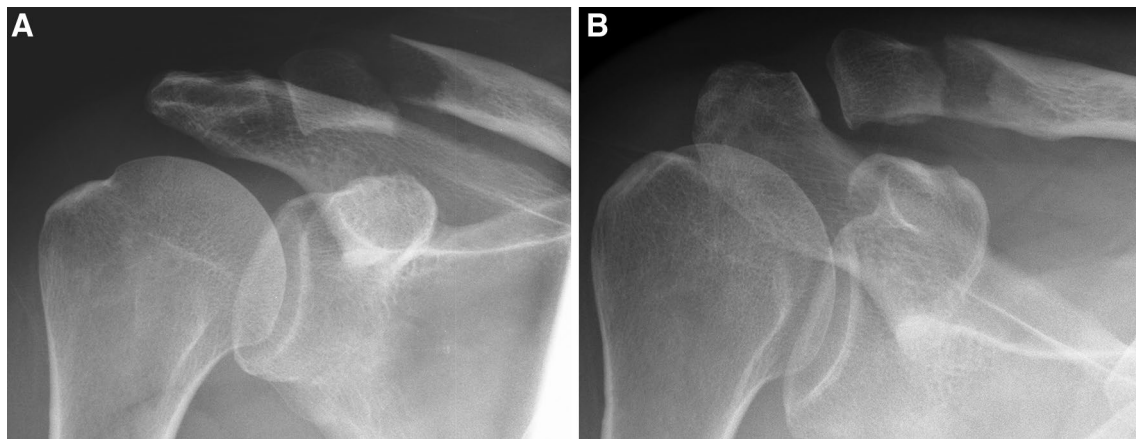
Preoperative radiographs of a Neer IIB fracture without weight show moderate displacement in the anterior–posterior view (a) and the anterior–posterior with 30° cephalic tilt (b)
